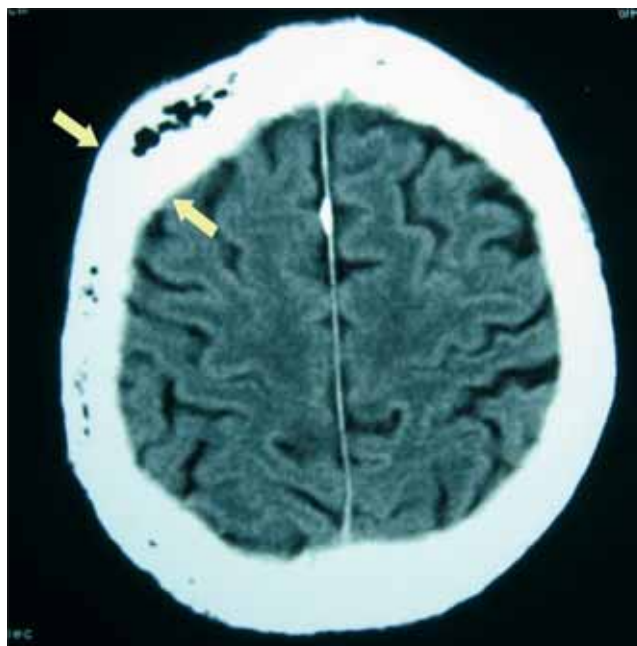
Head CT scan demonstrating focal thickening of the cranial vault.
